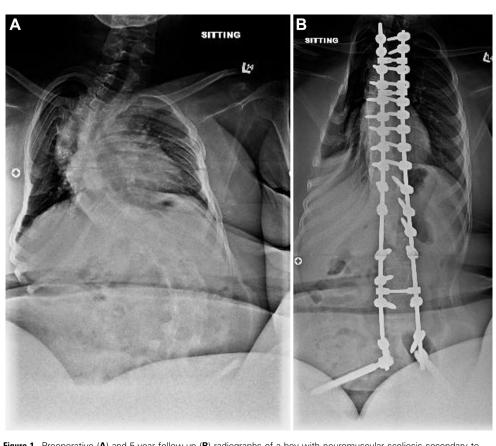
Preoperative (A) and 5-year follow-up (B) radiographs of a boy with neuromuscular scoliosis secondary to spinal muscular atrophy treated surgically with spinal fusion and sacral-alar-iliac pelvic fixation.
